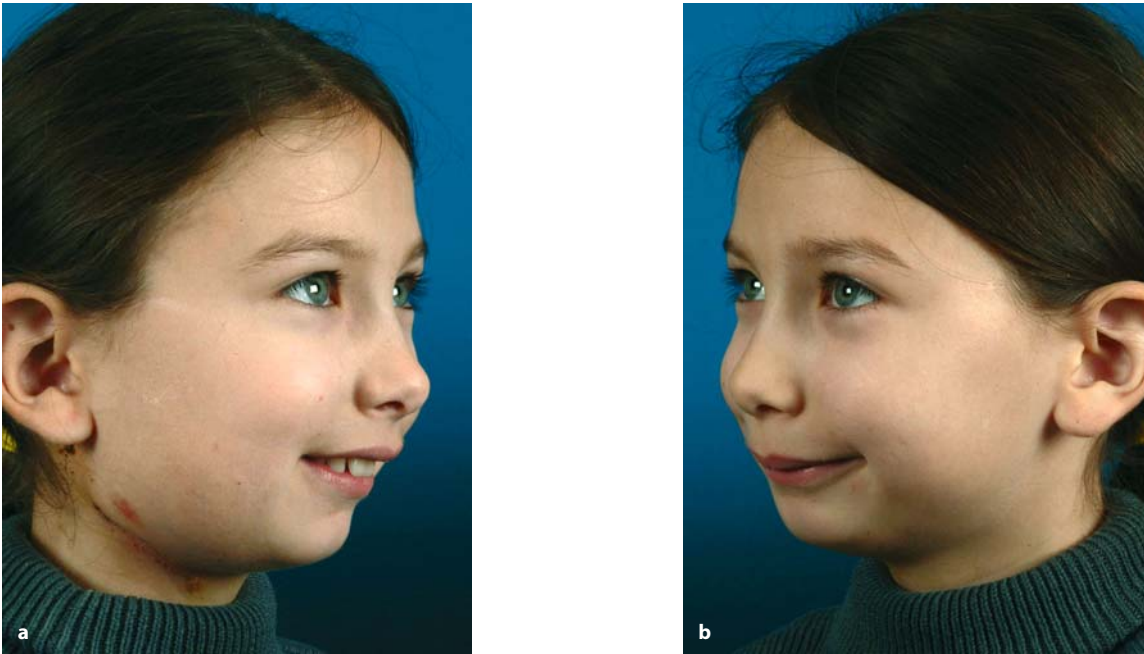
Post-distraction clinical right (a) and left (b) three-quarter views at 1 week after removal of the distraction device (3-D CT, patient B.R.)
